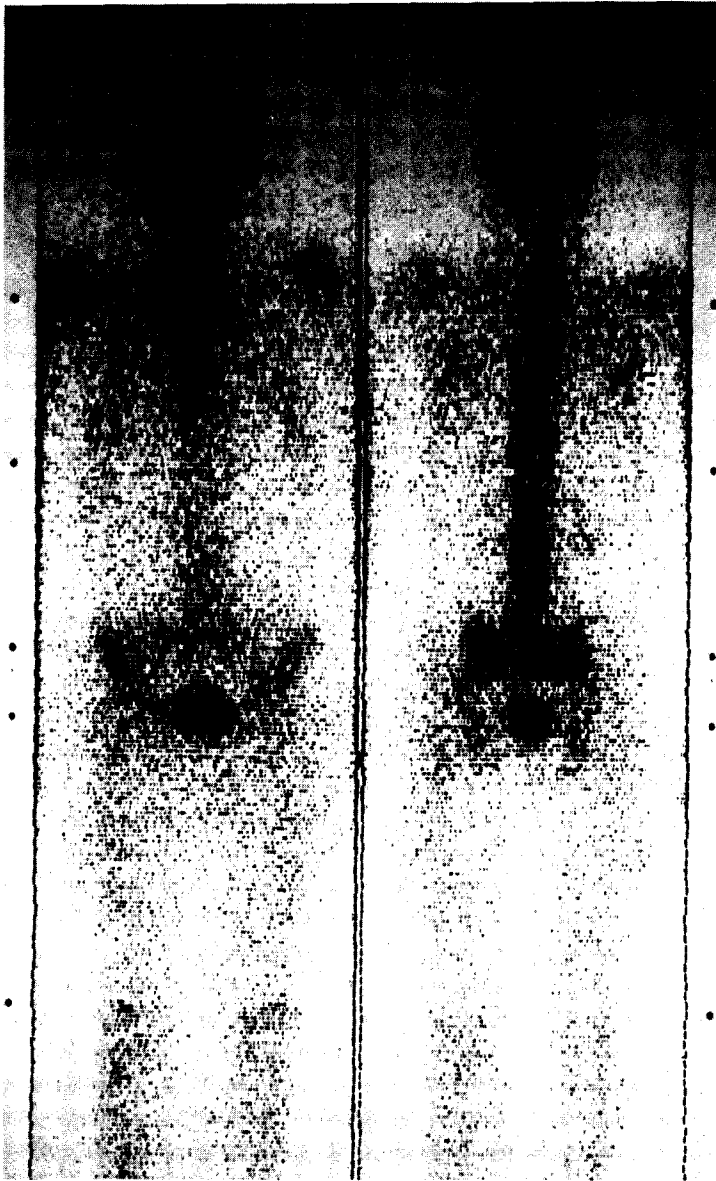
This patient was given 3.2 millicuries (mc) of fluorine-18. Two hours later anterior and posterior total body rapid survey scans were begun. A slight difference in the tracer concentration in the two shoulders was detected. The plain film examination demonstrated definite areas of osteonecrosis in both shoulders and the left knee.
